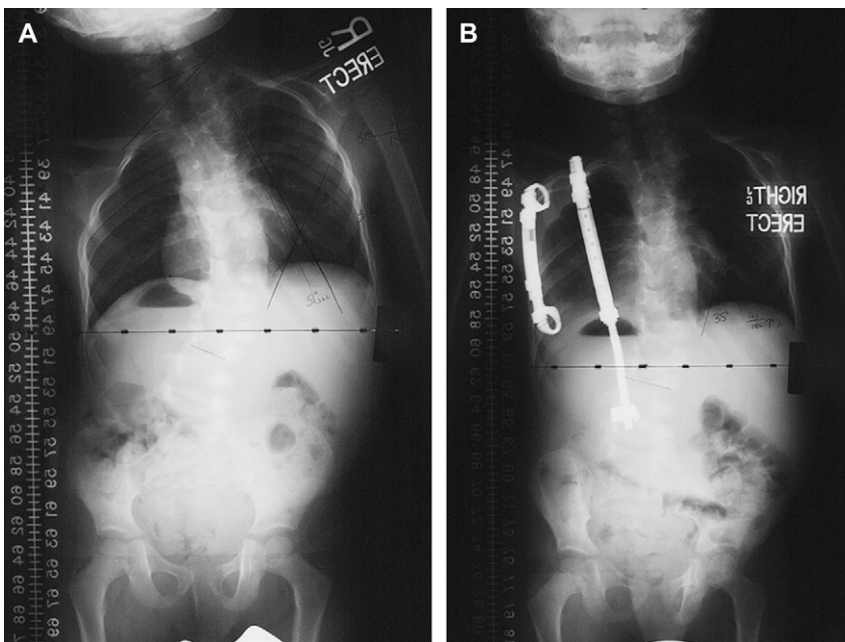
(A) Anteroposterior spine radiograph of a 3-year-old child with progressive congenital scoliosis. (B) Patient underwent placement of a rib-to-rib and rib-to-spine VEPTR. His curvature has been maintained, and he undergoes expansion every 4 to 6 months.
